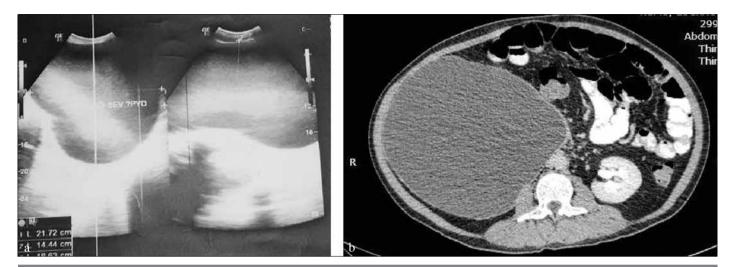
a,b. Ultrasonography of an adult male presenting with abdominal distension and pain, shows hugely dilated sac of the right kidney with internal echoes, suggestive of pyonephrosis (a). Contrast-enhanced computed tomography scan showing giant hydronephrosis of the right kidney (b).
